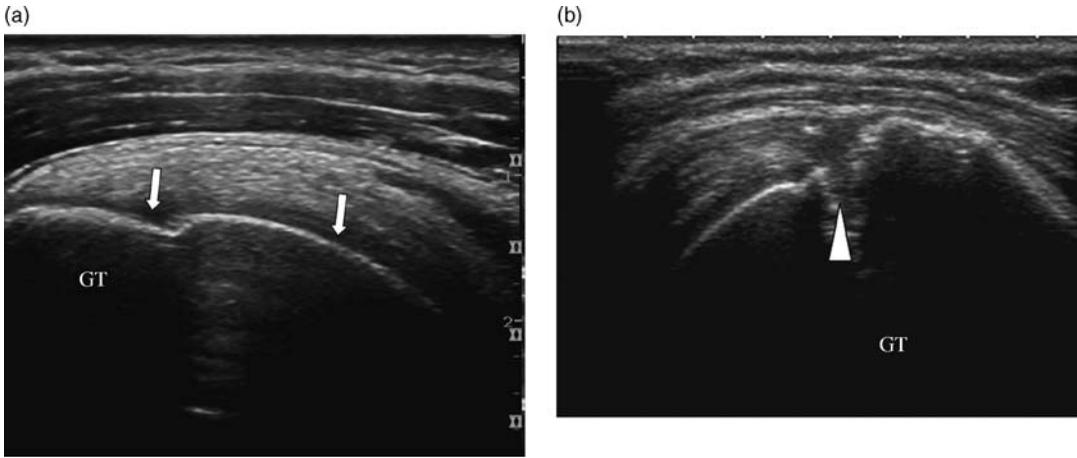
(a) Cortical bone: ultrasound of the normal greater tuberosity (GT) of the humerus demonstrating a smooth hyperechoic line consistent with cortex margin with posterior acoustic shadowing. (b) Fracture (arrowhead) GT with interruption of the normal smooth cortical line demonstrated in (a).
